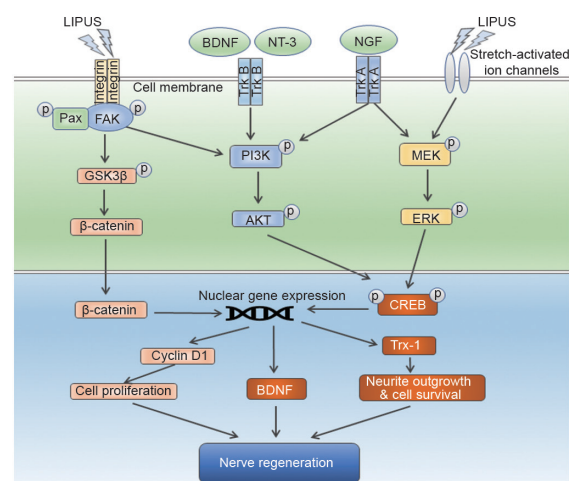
Cellular signaling pathways regulated by low-intensity pulsed ultrasound for peripheral nerve regeneration. LIPUS: low-intensity pulsed ultrasound; Pax: Paxillin; FAK: focal adhesion kinase; GSK3 β : glycogen synthase kinase 3 beta; BDNF: brain-derived neurotrophic factor; NT-3: neurotrophin-3; PI3K: phosphatidylinositol 3-OH kinase; NGF: nerve growth factor; Trk: tyrosine kinase; MEK: mitogen-activated protein kinase/ERK kinase; ERK: extracellular signal-regulated protein kinase; CREB: cAMP-regulated enhancer B.
